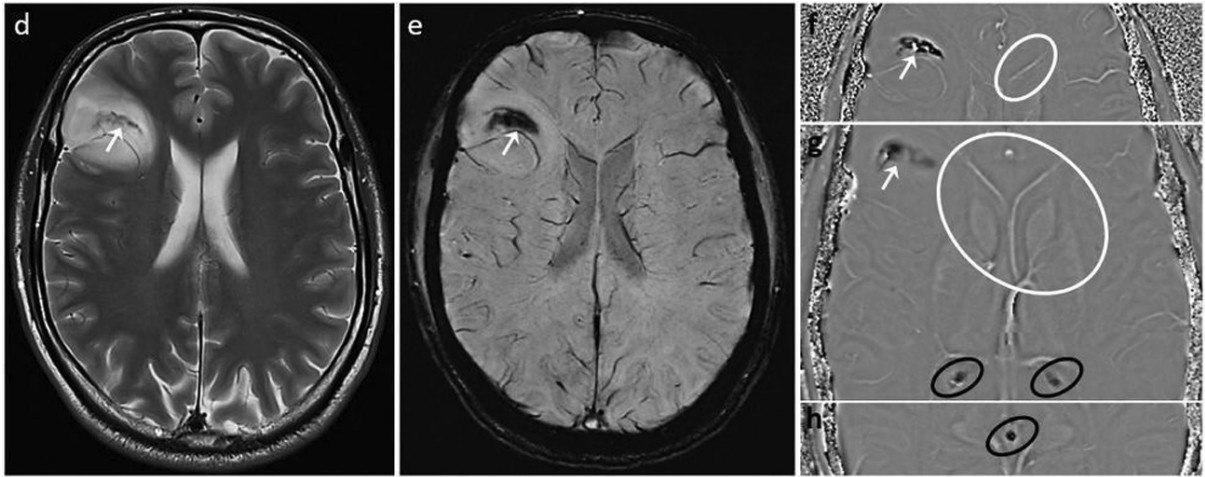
Calcification in low-grade oligodendroglioma (d–h; *IDH*-mutant, 1p/19q-codeleted): axial MR images demonstrate a heterogeneous, hyperintense lesion in the right frontal lobe (d, white arrow), with internal calcification evident by blooming artifact on SWI (e, white arrow). The corresponding area is hypointense on filtered phase images (f, g; white arrows), matching the signal of the calcified choroid plexus (g, dark circles) and pineal gland (h, dark circle), in contrast to the internal cerebral veins (f, g, white circles). These findings support calcification rather than hemorrhage, with internal veins serving as a reference for hemorrhagic signal and the choroid plexus/pineal gland for calcification. *Adapted from (Azizova et al., 2025b), licensed under CC-BY-4.0.*
